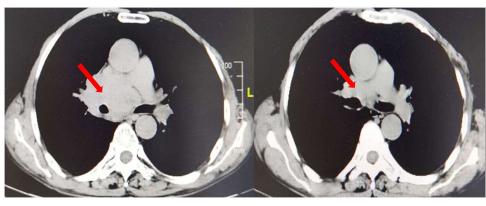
Computed tomographic scan results of the changes for target lesions in 1 patient with extensive-stage small-cell lung cancer after anothinib monotherapy.
